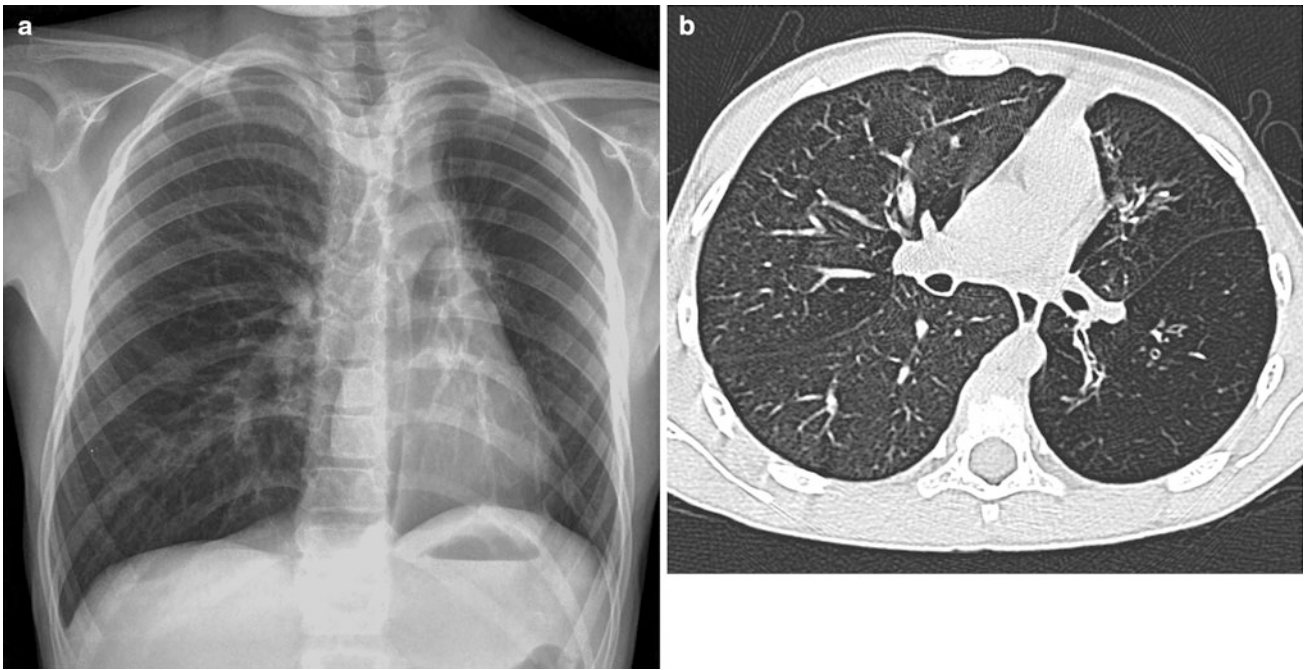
Frontal chest X-ray (a) of a 3-year-old boy with a Swyer James Syndrome. Note small hyperlucent left lung and large compensatory right lung. High resolution CT (b) shows characteristic
